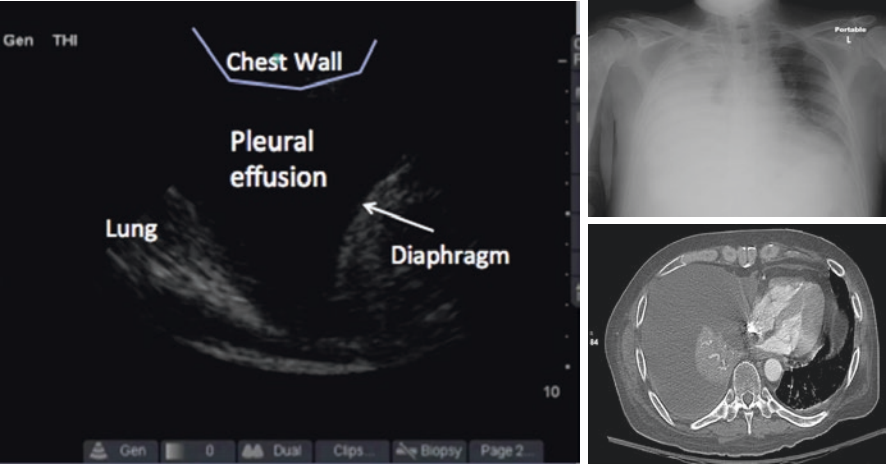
Pleural effusion imaged in the right lateral lung zone imaged with phased array transducer and comparison to CXR and CT scan showing complete opacification of the right hemithorax
